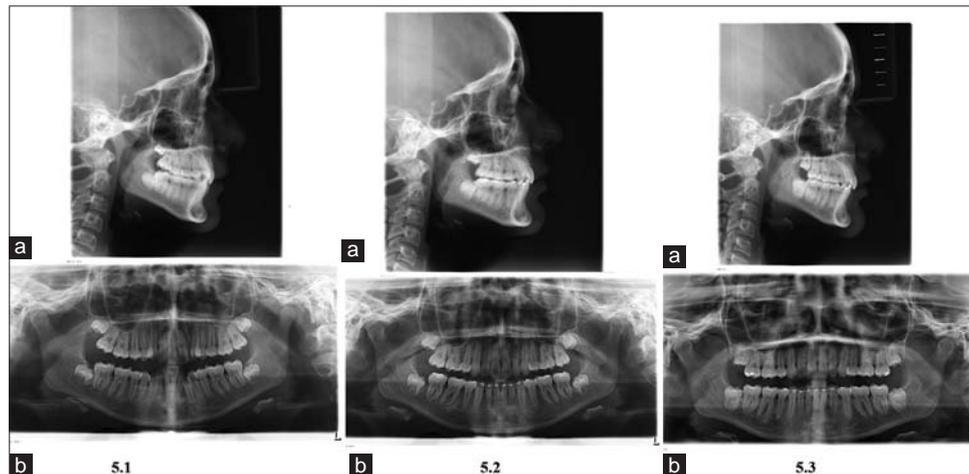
5.1: Pre-treatment radiographs (a) lateral cephalogram (b) OPG; 5.2: Post-treatment radiographs (a) lateral cephalogram (b) OPG; Figure 5.3: The post-treatment 3-year follow-up (a) lateral cephalogram (b) OPG
